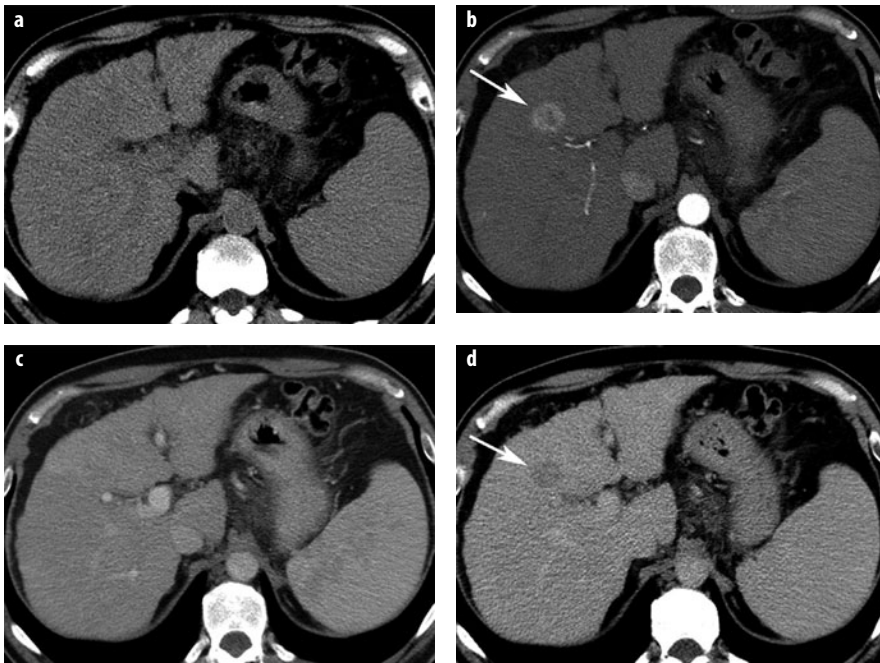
a-d. Hepatocellular carcinoma (HCC) quadruple-phasic CT for detection and characterization. a Noncontrast CT shows liver cirrhosis and splenomegaly. In segment 4, a lesion is only faintly seen. b In the late arterial phase, a hypervascular HCC is depicted in segment 4 (*arrow*). c In the venous phase, the lesion is not visible. d The delayed-phase scan reveals lesion washout; the lesion is now hypoattenuating (*arrow*). The combination of arterial hypervascularity and washout is a highly specific sign of malignancy
